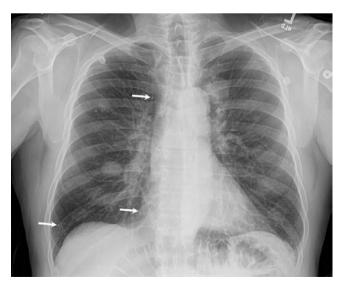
A 67-year-old man with prostate cancer. Frontal radiograph shows embolized brachytherapy radiation seeds (arrows). Note pulmonary metastases
